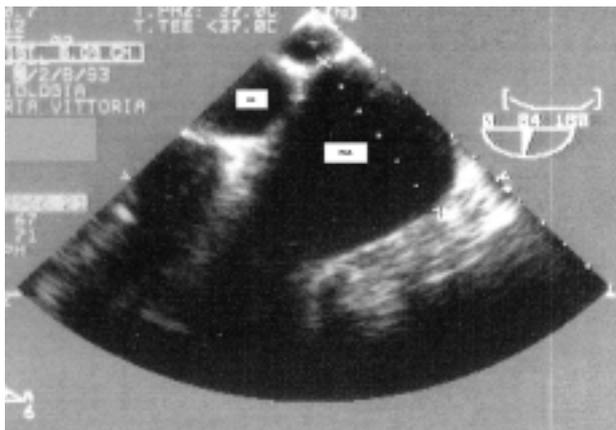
Transesophageal echocardiography: a multiplane transesophageal view at 84° obtained from the upper esophageal position. It shows a pulmonary artery aneurysm (PAA) with a diameter of approximately 6 cm. Ao = aorta.
